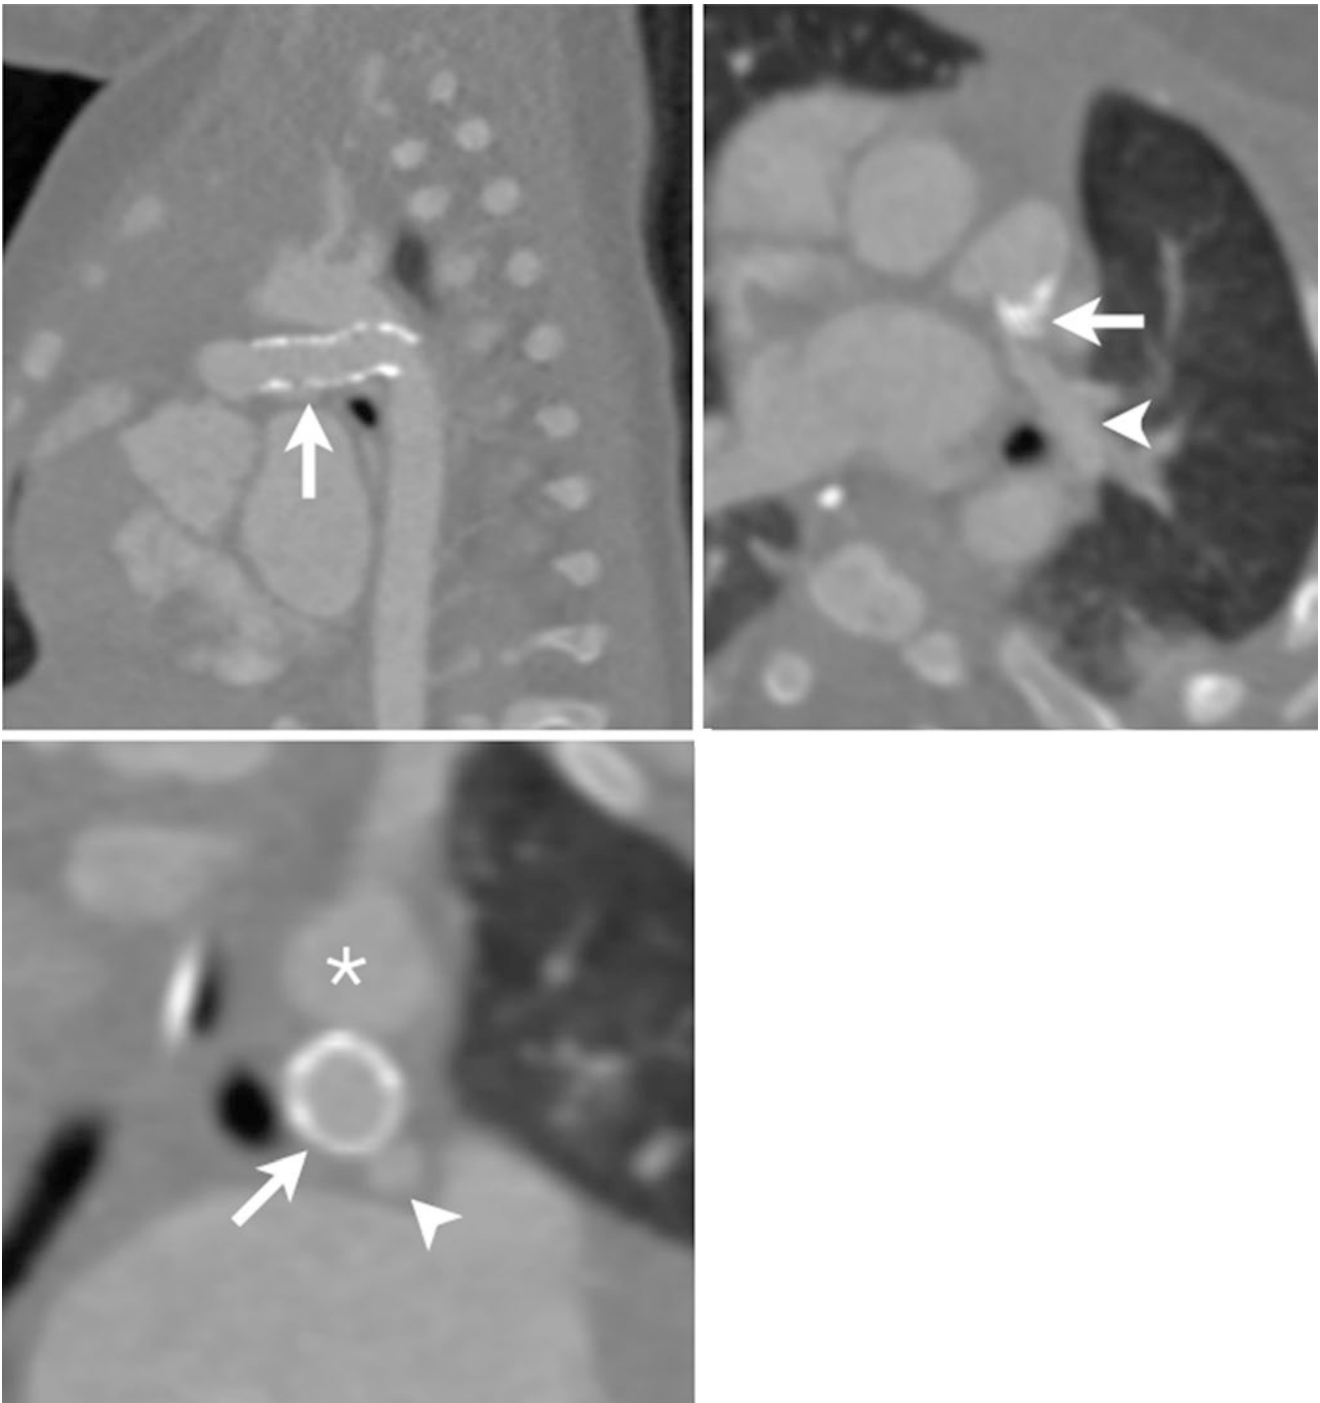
Proximal left pulmonary artery compression following patent ductus arteriosus (PDA) stenting in a neonate, contrast-enhanced CT. Upper right image (sagittal view) shows the widely patent stent in the PDA (arrow). Upper left image (axial view) shows the left
